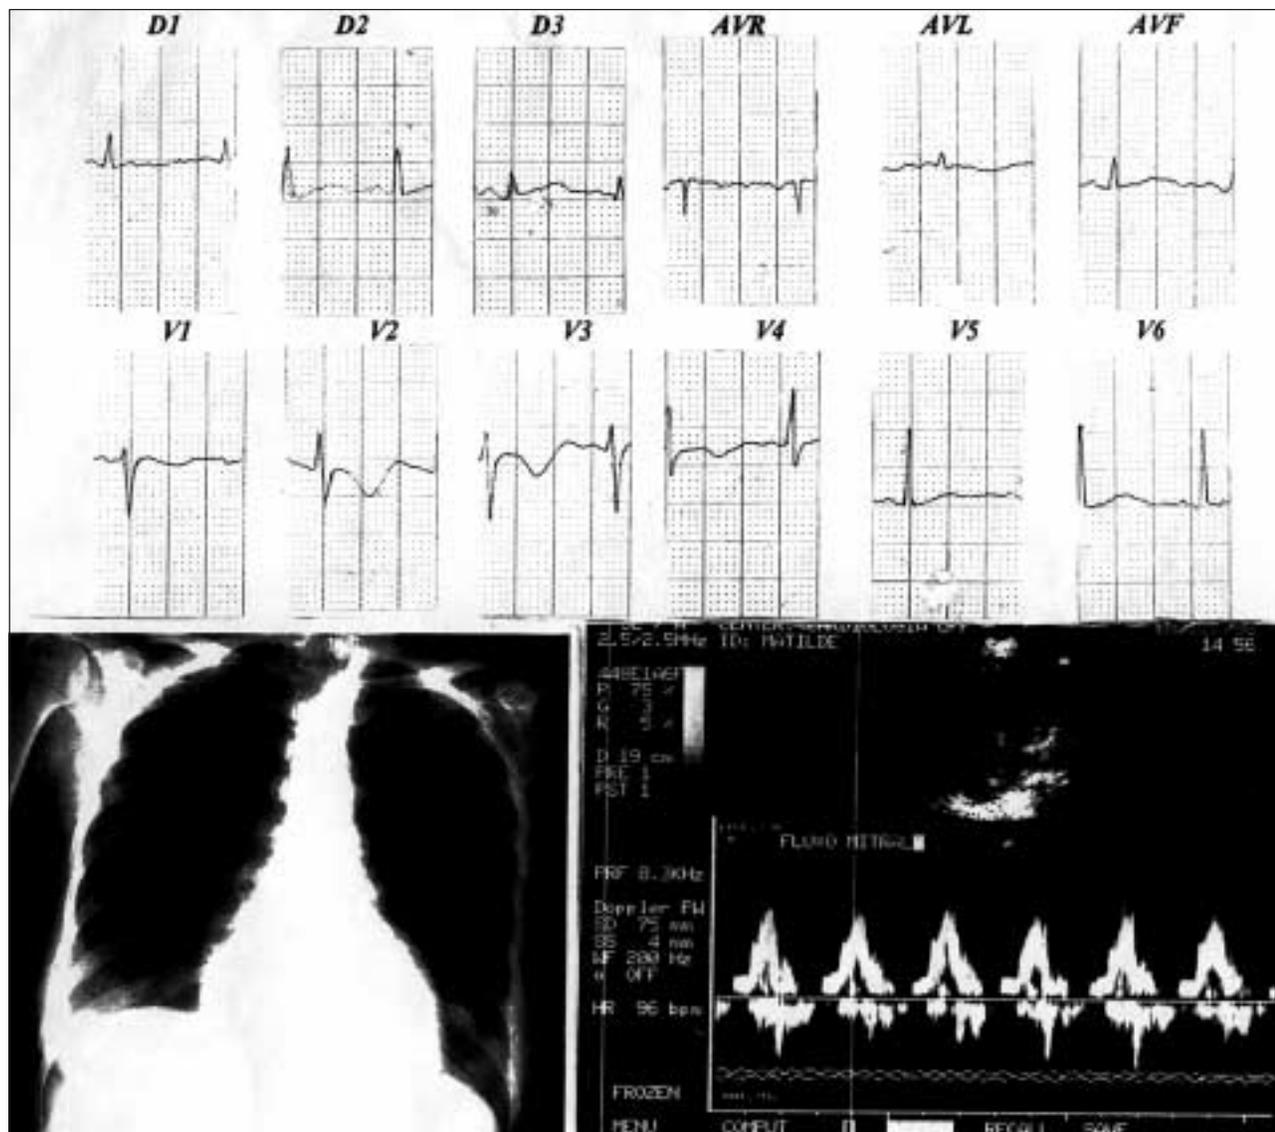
Case 14 - Patient with mild ST-T segment abnormalities and mild increase in left chambers. Doppler tracing shows decreased velocity of the mitral flow and abnormal relaxation pattern.
